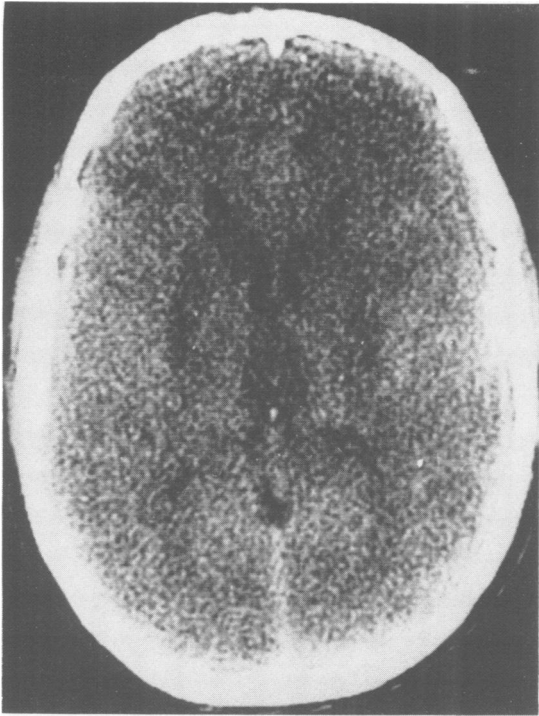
CT brain scan showing symmetrical areas of low density in the putamen, caudate nucleus and thalamus.
